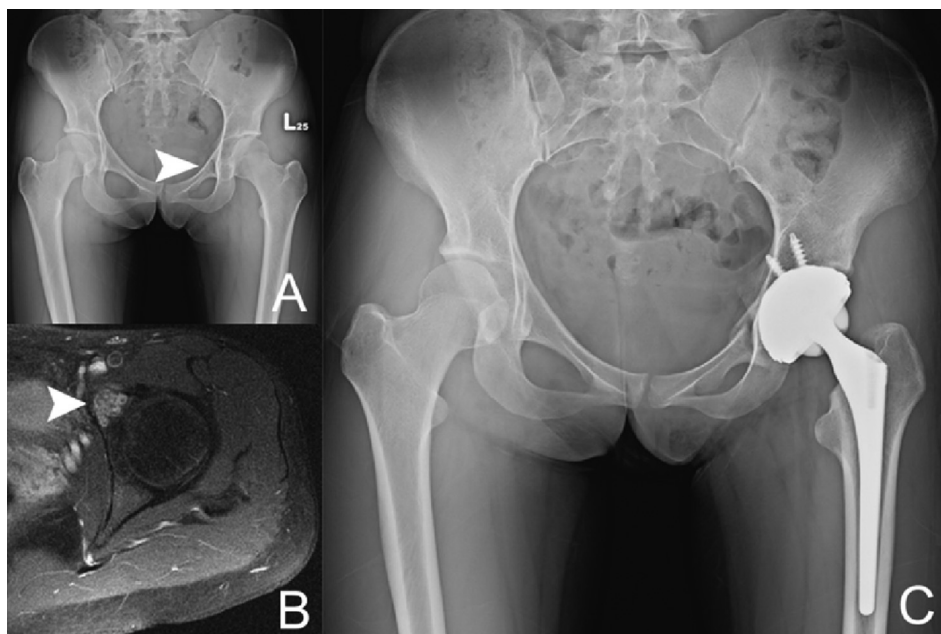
(A) Patient 4 had the tumor lesion at left acetabulum (arrow); (B) T2-weighted MRI showed periarticular involvement (arrow); (C) total hip arthroplasty was done after intralesional treatment with adjuvant therapy. MRI = magnetic resonance imaging.
